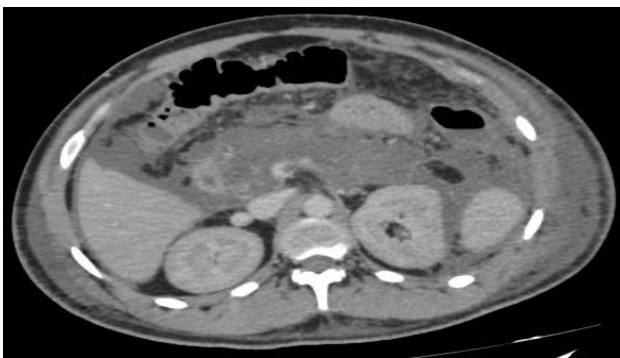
CT scan demonstrating acute pancreatitis with no enhancement.
